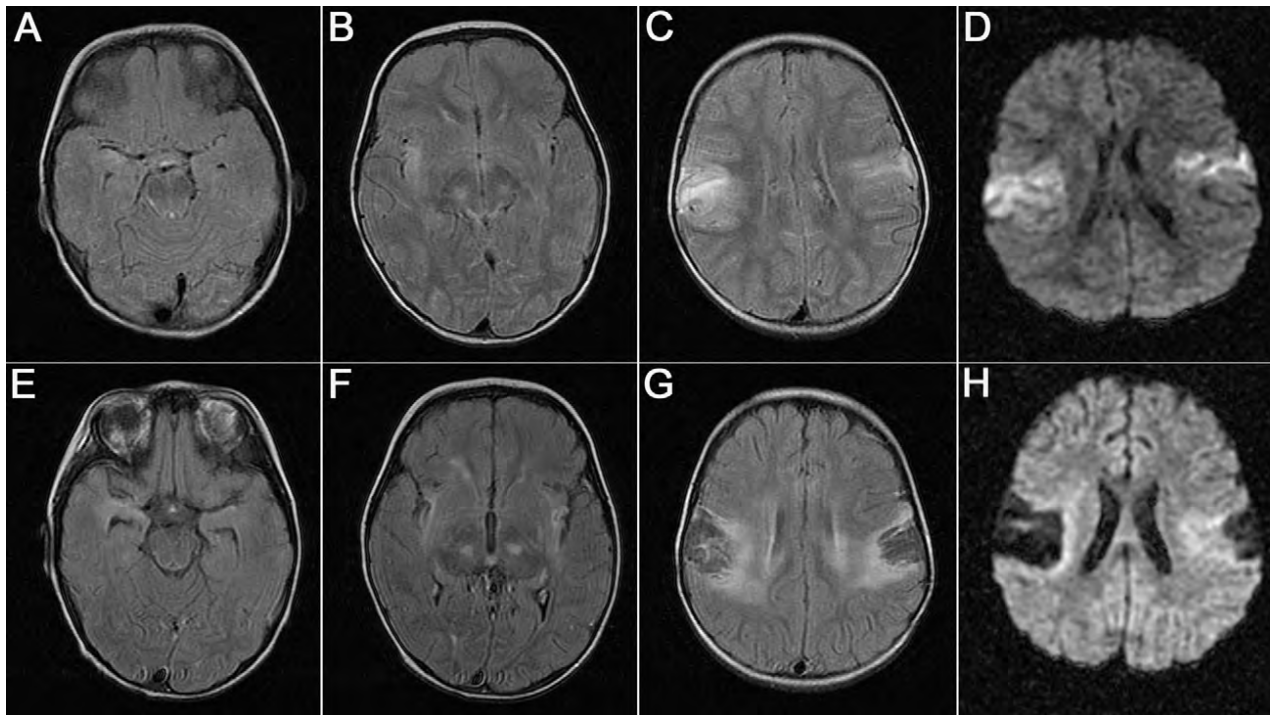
MRI findings in a patient who developed HSE followed by anti-NMDAR encephalitis. A-D, The MRI findings during the first week of HSE. A-C, Increased T2-FLAIR signal was demonstrated in the right medial temporal lobe, right insula, posterior basal ganglia, and bilateral opercular regions, and D, increased signal in diffusion weighted images (DWI). E-H, The MRI obtained during admission for anti-NMDAR encephalitis, 1 month after HSE onset, showed no additional changes other than the interval evolution of areas of encephalomalacia in opercular regions and hippocampal atrophy.
